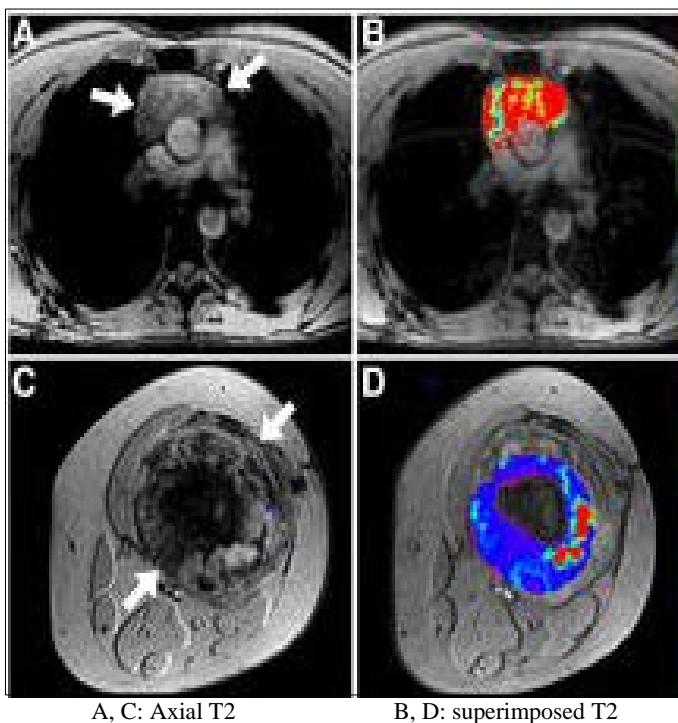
Different MRI enhancement and different TAM quantities in Lymphomas
